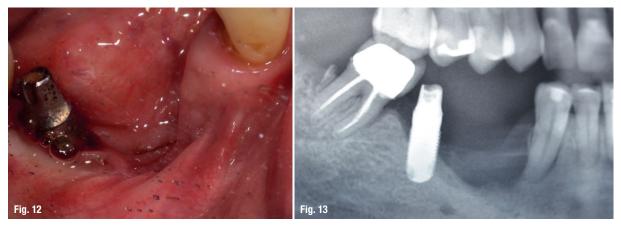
Complete closure of the wound with new epithelium (one year post-op). Fig. 13: One year post-op radiograph.
